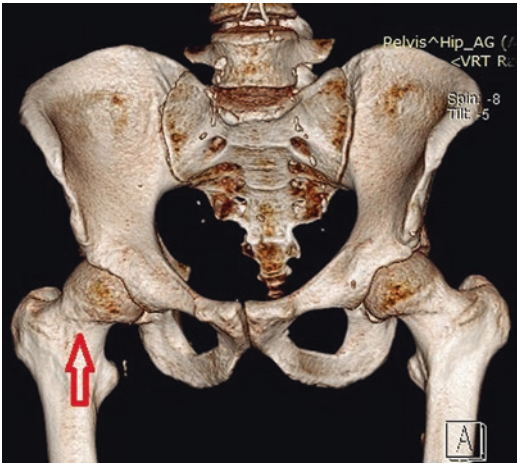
3D CT reconstruction of right hip (arrow shows cam lesion)
